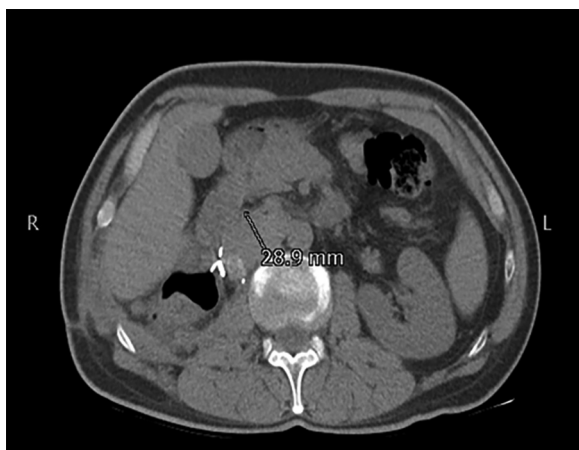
The CT scan reveals interval follows radical nephrectomy and lymphodec-tomy and increase in caval node at renal hilum on right side measuring 29 mm in short axis. A simple renal cortical cyst evident at the lower pole of the left kidney.
